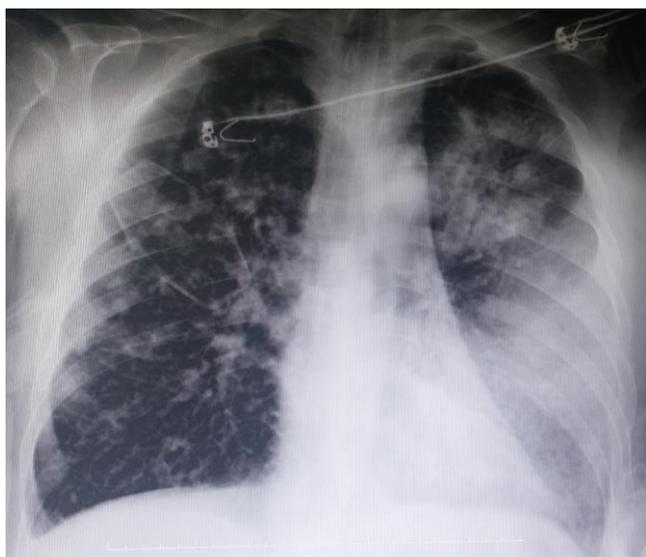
Chest x-ray in the intensive care unit
